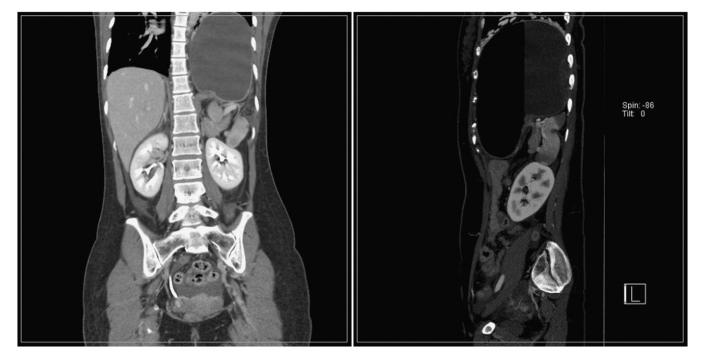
Abdominal computed tomography scanning demonstrates marked distension and air-fluid level of stomach located in the left hemithorax.
